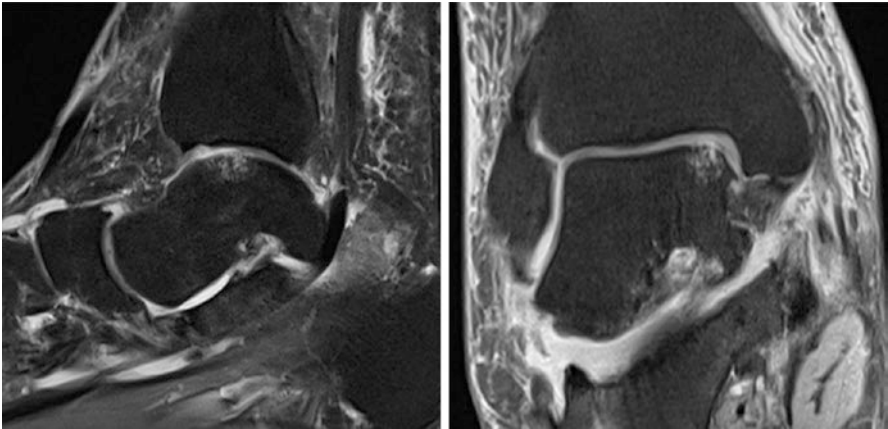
MRI: Sag PDFS and coronal PDFS showing osteochondral lesion of the superomedial talar dome (Courtesy: Dr. Rajesh Botchu, Consultant MSK Radiologist, Royal Orthopaedic Hospital, Birmingham, UK)
